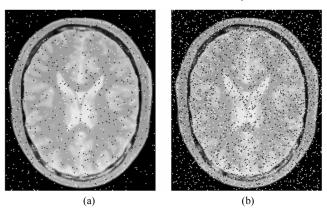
The known-result registration datasets. (a) The 2D slices through 3D volume of PD MRI image with 3% salt-and-pepper noise added, and (b) the 2D slice of PD MRI image with 10% salt-and-pepper noise added.
